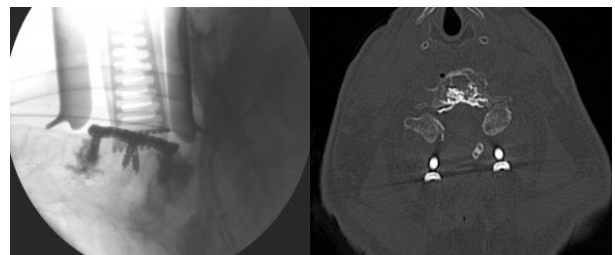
C. Intra-canal cement leakage was detected intraoperatively, asymptomatic and considered irrelevant in the axial sections of the cervical CT.
